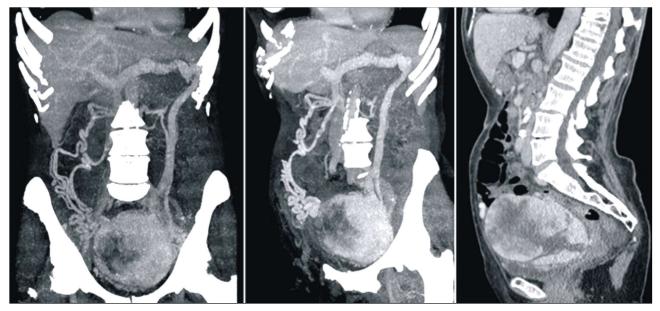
Abdominal computed tomography scan showing the pelvic omental SFT
